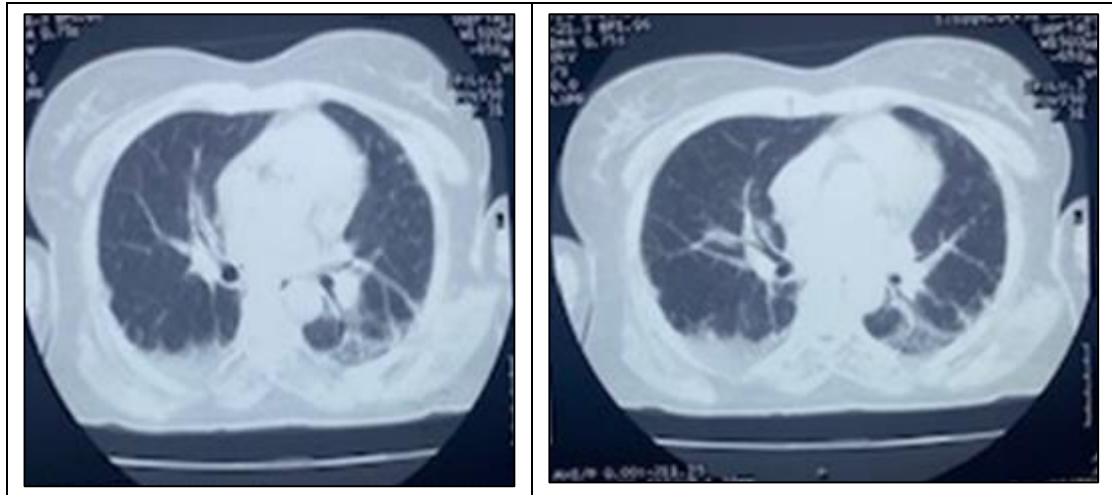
Chest CT showed bilateral basal ground-glass opacities
